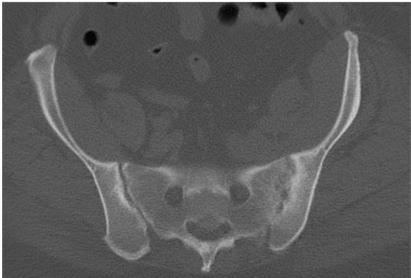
Final CT follow up showing ankylosis of the left sacroiliac joint and sclerosis as a result of the infective process.
